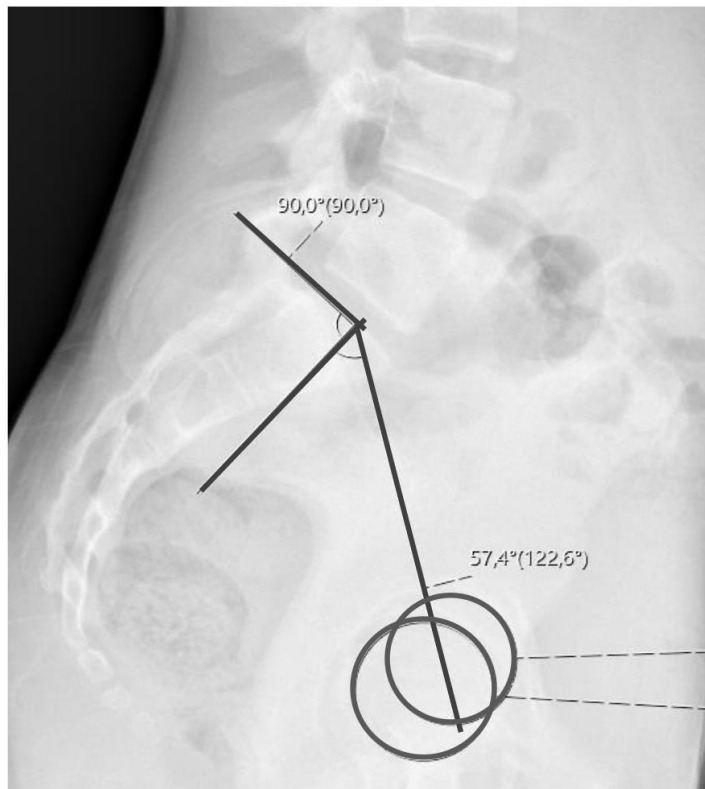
Measurement of the pelvic incidence in a lateral lumbar spine radiography.
